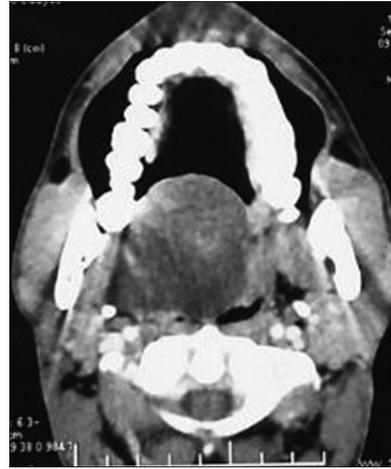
Computed tomography scan showing a hypodense lesion with thin peripheral enhancing wall occupying the right oral cavity, crossing the midline, and extending to the right lateral pharyngeal wall
